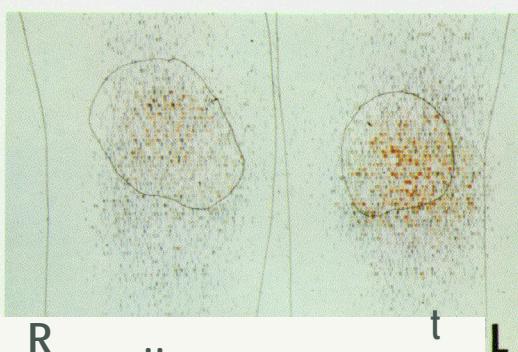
Case 1. Corresponding scintigram: increased radionuclide uptake on the left side, also in the lateral part of the knee.
